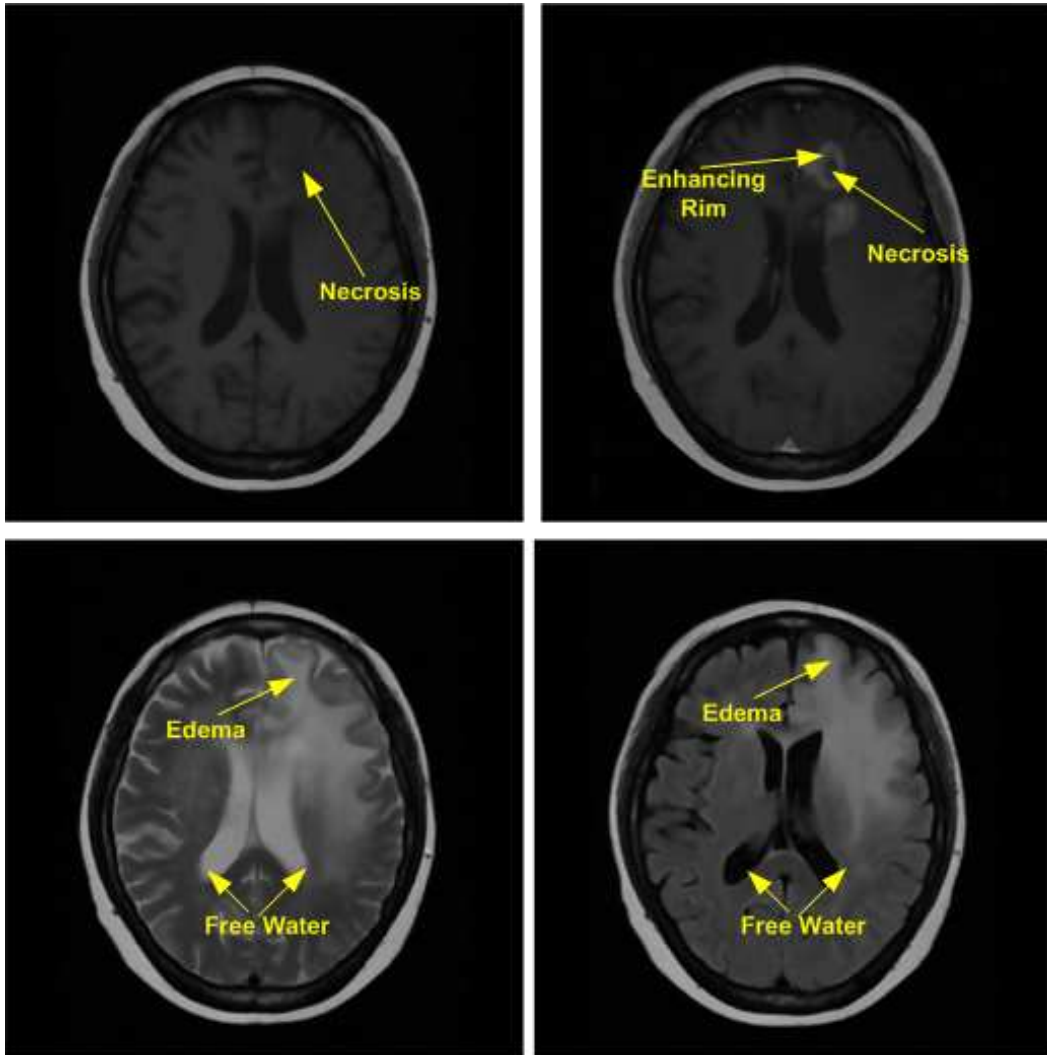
MRI scans of a glioblastoma tumor. (Top-Left) T1-weighted (Top-Right) T1-weighted after post gadolinium injection (Bottom-Left) T2-weighted (Bottom-Right) FLAIR image. Edema appears dark in T1 and T1-C (Contrast Enhanced) but bright in FLAIR and T2. Ventricles appear dark in T1, T1-weighted and FLAIR but bright in T2. Necrosis appears dark in T1 and T1-C, and brighter than edema in FLAIR and T2. The enhanced area is bright in T1-C.
